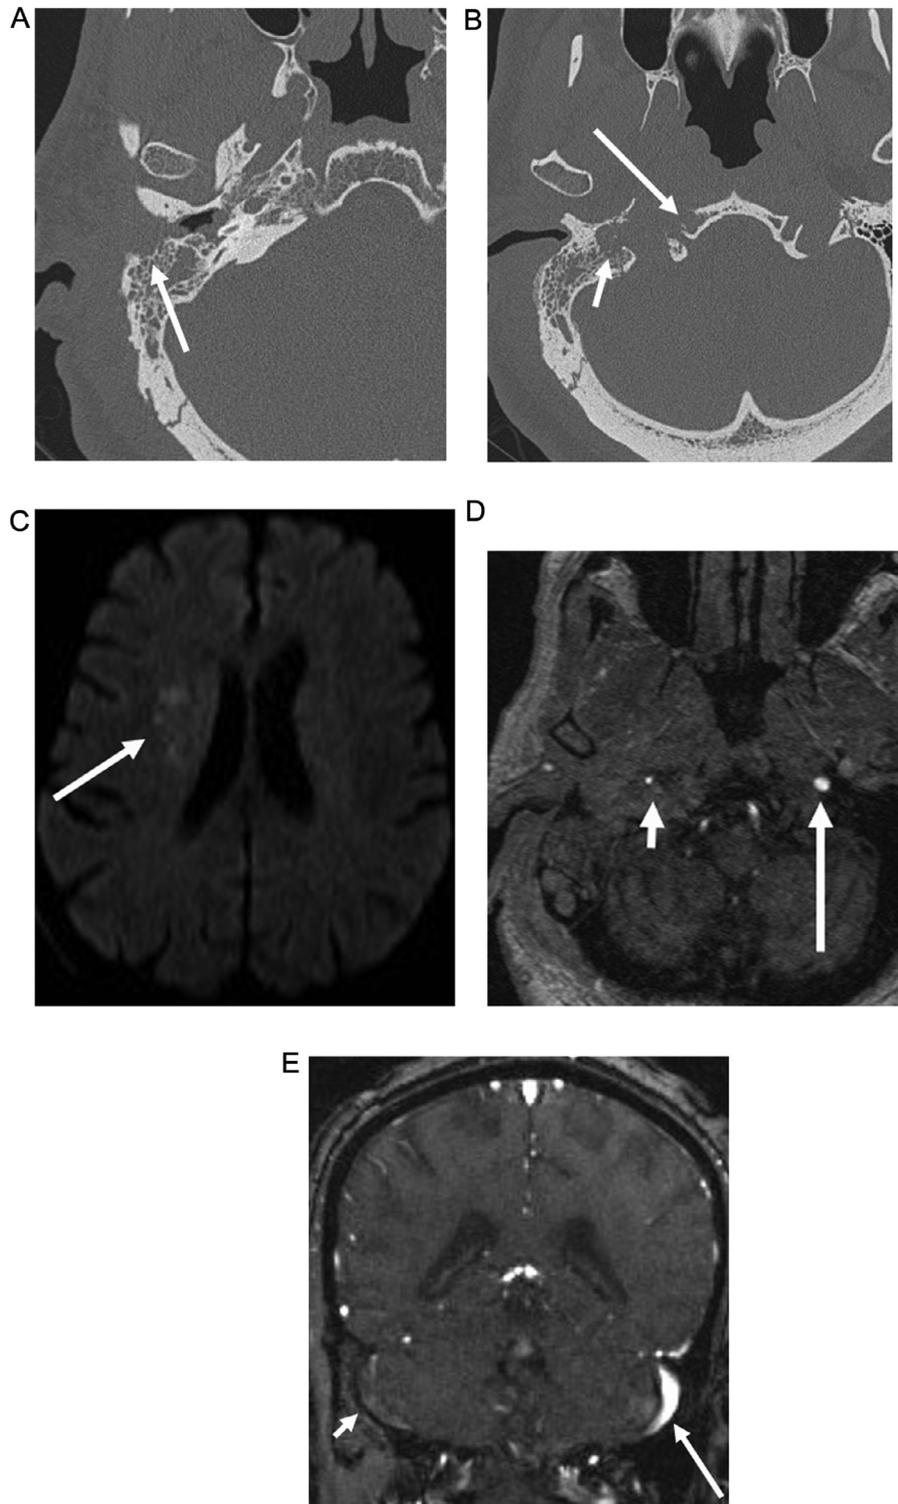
70 m h/o diabetes with staphylococcus infection with NOE, mastoiditis, and facial weakness. Axial CT images show soft tissue within the EAC with erosion of the roof and posterior wall/mastoid air cells (arrow A) and erosion of the skull base more inferiorly (short arrow B) including the clivus (long arrow B). DWI (C) shows infarcts within the deep white matter of the right hemisphere (arrow) which may be in the carotid watershed. Source image from MRA (D) shows marked narrowing of the right internal carotid artery (ICA) adjacent to the infection (short arrow) compared to the normal left ICA (long arrow). Source image from MRV shows lack of flow signal consistent with slow flow vs occlusion of the right sigmoid sinus (short arrow) compared to the normal left sigmoid sinus (long arrow).
